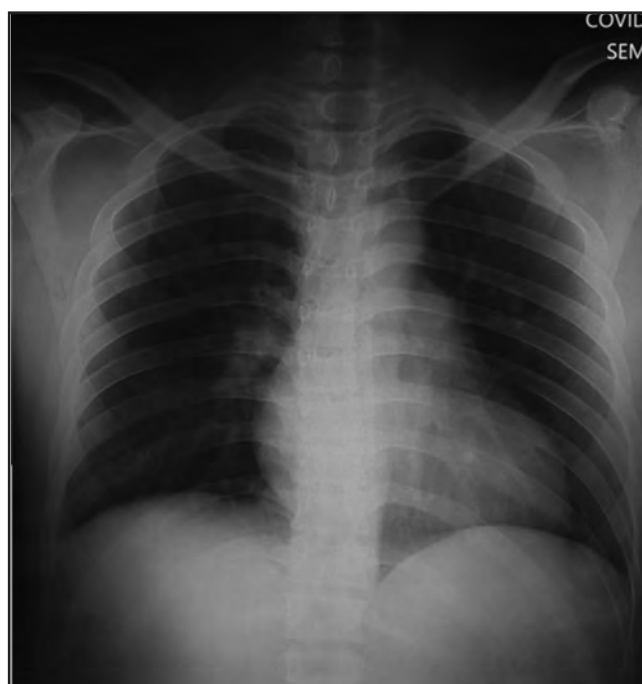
Chest X-ray showed clear lung field.
